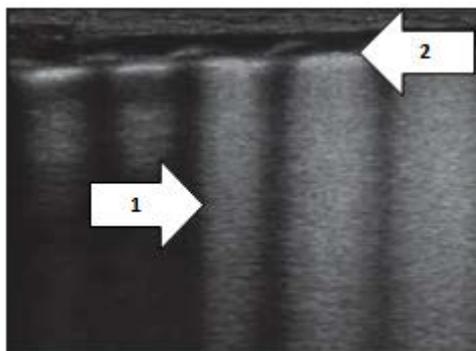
Chest ultrasound of a case with TTN showing double lung point sign (Arrow 1) and thickened pleural line (Arrow 2).
